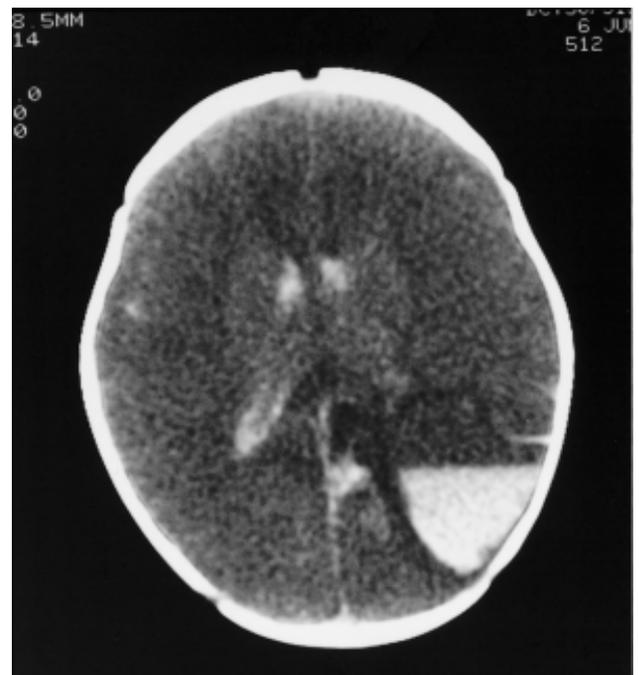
Non-contrast CT showing a left fronto-parietal haematoma, subarachnoid and intraventricular haemorrhages with diffuse cerebral oedema.
